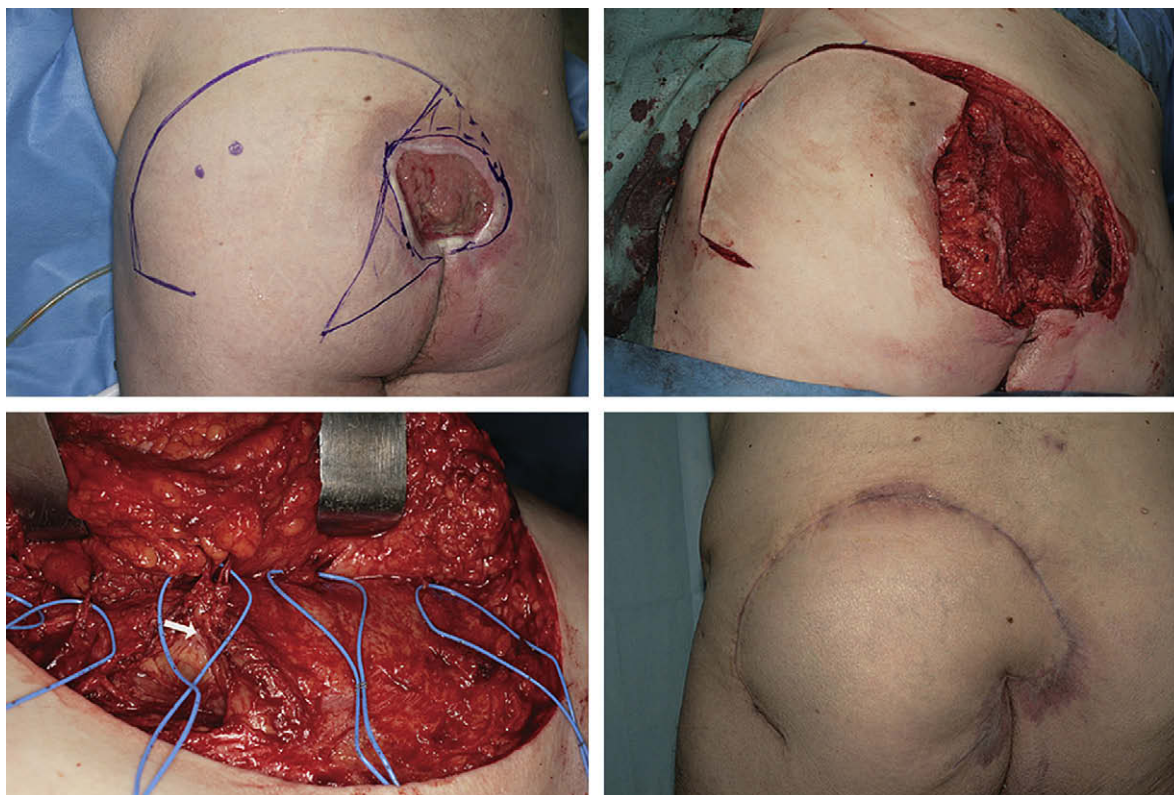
Case 3 (no. 21 in Table 1) Soft-tissue defect caused by pressure sore in the sacral area in a 62-year-old patient. Defect closure was achieved with a rotation-advancement flap of the gluteal area, including five perforator vessels (peninsular free-style local perforator flap; type III). Postoperative recovery was uneventful. Pressure sore and flap design showing marked Doppler signals (top left); tissue defect after debridement (top right); peninsular flap of gluteal area showing five perforator vessels preserved (bottom left). Note the intramuscular dissection of a large central perforator in order to achieve adequate flap mobilisation (arrow bottom left); postoperative result after 3 months (bottom right).
